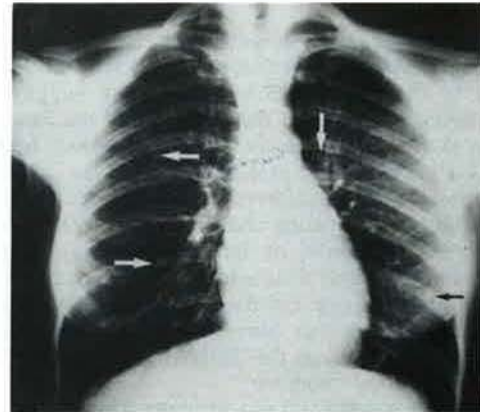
Chest X-ray showing small nodular opacities in the right upper and middle lobes and in the left lower lobe.
